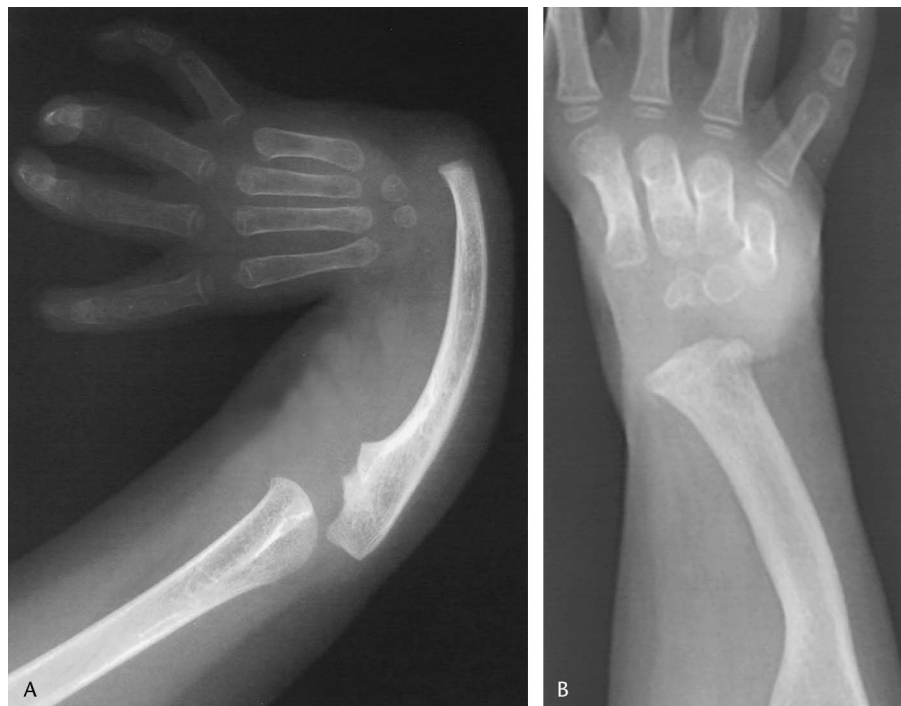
A, Preoperative anteroposterior view radiographs of the right hand and wrist of the patient shown in Figure 5, demonstrating Bayne type IV deformity. B, Followup anteroposterior view radiographs of the right hand and wrist of the patient shown in Figure 1, demonstrating correction of Bayne type IV deformity.
